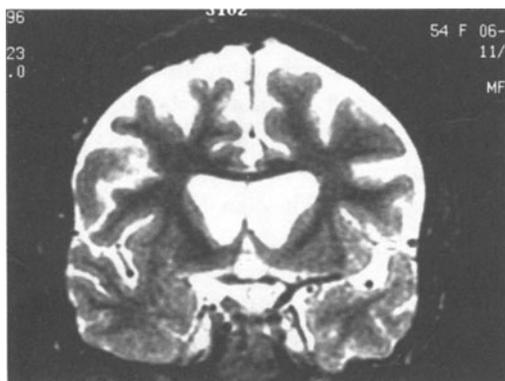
Huntington's disease. Case 19-4. MRI. (T2) Refer to text. Marked atrophy of cerebral cortex and of caudate nucleus is evident in this patient with a familial history of the disorder and a significant increase in the CAG trinucleotide repeats.
